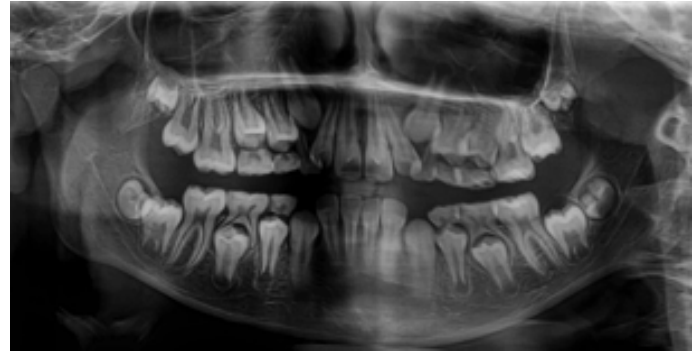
Panoramic radiograph showing before orthodontic treatment, there were no signs of lesion at anterior mandible.
